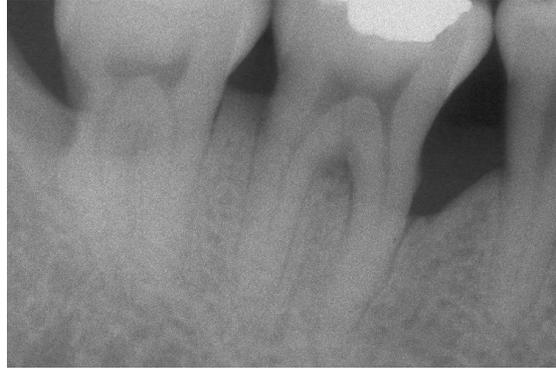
Radiograph taken at 1 year
